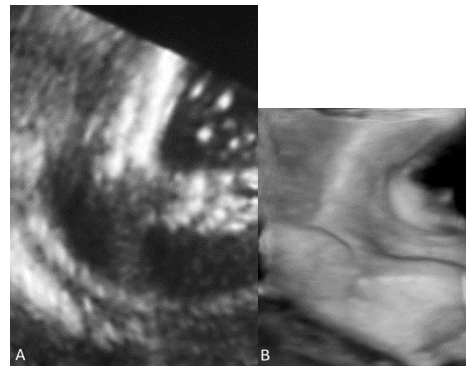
Fetal ultrasound clubfoot. A. Routine. B. 3D.
